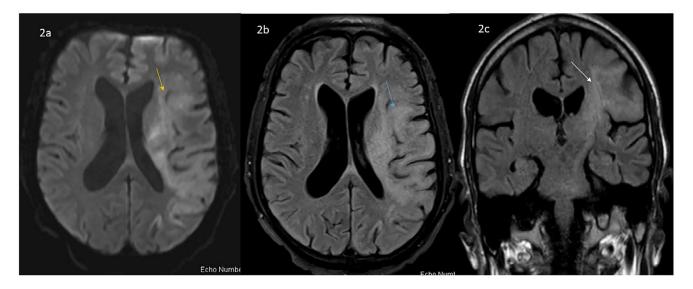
Diffusion weighted imaging (DWI) axial (2A; yellow arrow), FLAIR axial (2B; blue arrow) and FLAIR coronal (2C; white arrow) six months after initial presentation, DWI (2A) and FLAIR (2B) demonstrated interval expansion of restricted diffusion and FLAIR hyperintensity throughout large portions of the left frontal, parietal, and temporal lobes with associated mass effect. Findings were most consistent with infiltrating glioma (gliomatosis cerebri)
